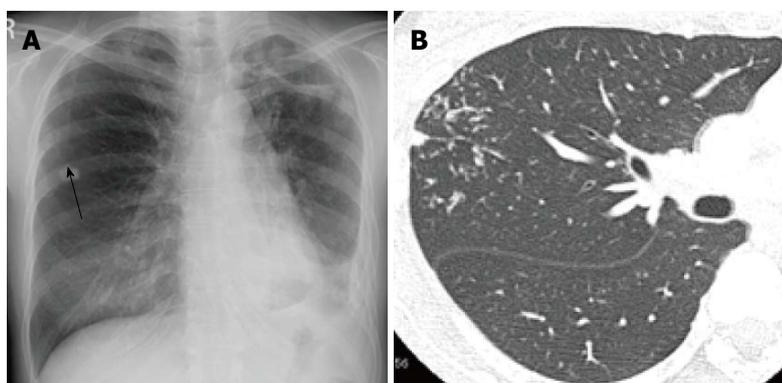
Postprimary tuberculosis in a woman in her 40s. A: Chest radiograph shows faint nodular opacities in the right middle lung field (arrow). There is also volume loss of the left lung with patchy consolidations and thickening of the pleura and possible left pleural effusion, indicative of old tuberculosis; B: Thin-section computed tomography demonstrates centrilobular branching opacities (tree-in-bud appearance) in the right upper lobe (arrows). The branching opacities are denser, more distributed and more peripherally located than those of ordinary bronchopneumonia (compare with Figure 3).
